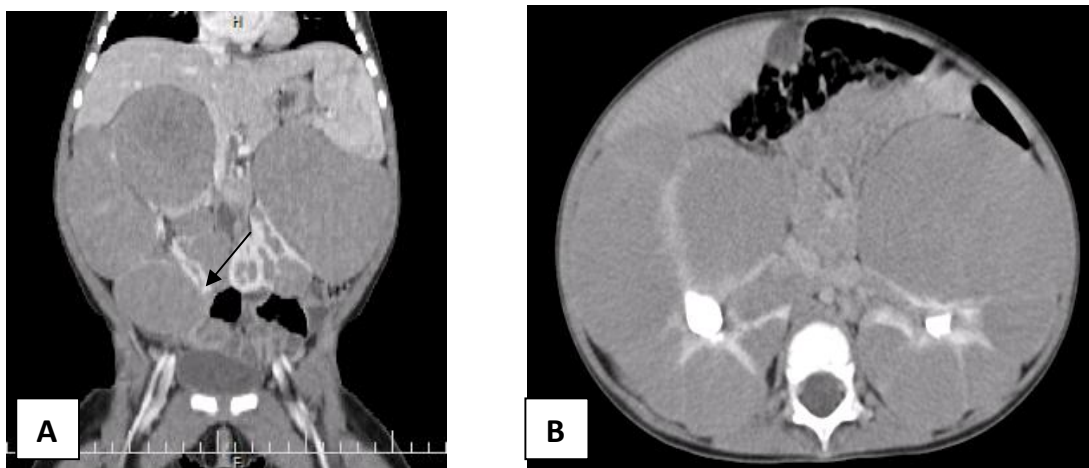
Coronal(A) and Axial(B) contrast enhanced CT scan
